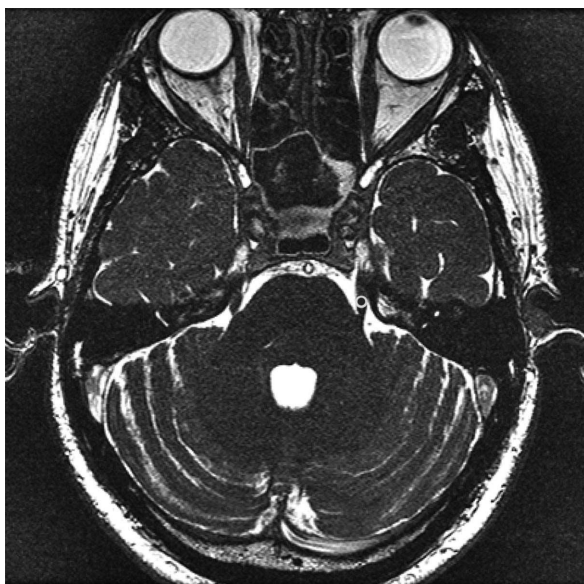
Axial MRI scan utilizing Fast Imaging Employing Steady state Acquisition scan to demonstrate the left trigeminal nerve and the position of the 4 mm collimator 50% isodose line over the root entry zone of the nerve.
